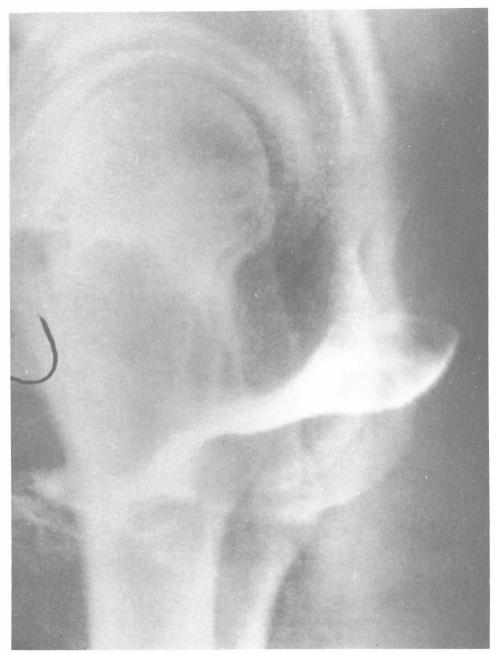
The same patient is straining, as by a Valsalva maneuver, which accentuates the horizontal axis of the upper vagina (St. Francis Hospital, x-ray 69–3159, courtesy of Dr. Paul J. deMarsovsky, radiologist). (From Nichols, D. H., Milley, P. S., and Randall, C. L.: Significance of restoration of normal vaginal depth and axis. Obstet. Gynecol. 36:251–256, 1970; reproduced with permission of The American College of Obstetricians and Gynecologists.)
